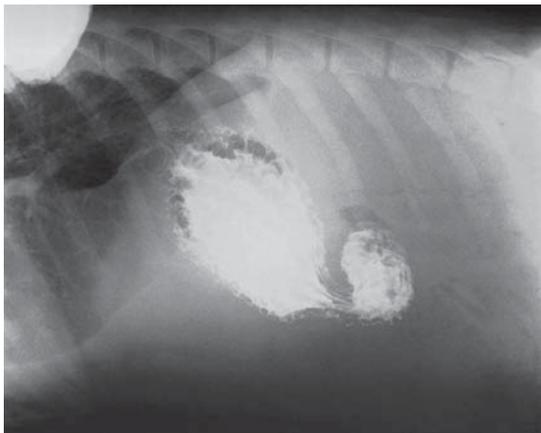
Lateral thoracic radiograph using contrast to demonstrate resolution of gastric herniation.
